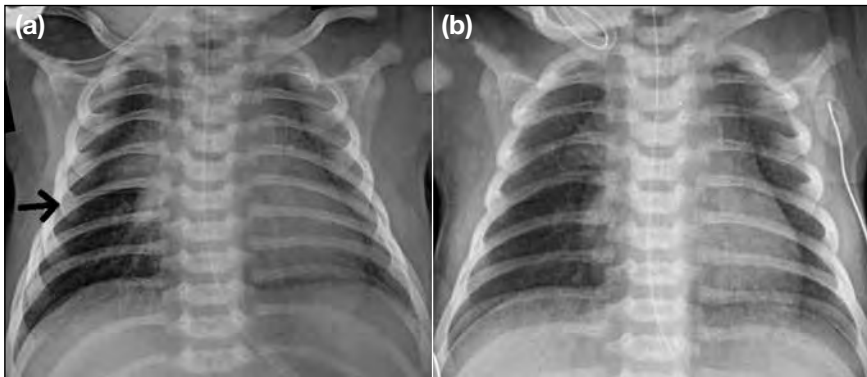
Transient cardiomegaly in transient tachypnoea of the newborn. A 40+4 weeks post-term baby girl delivered by emergent Caesarean section due to failed induction of labour, presented with respiratory distress at birth. (a) Chest X-ray on day 0 showing hyperinflated lungs, increased perihilar streaky opacities and thickened right horizontal fissure (arrow), as well as prominent cardiac shadow. (b) Chest X-ray on day 1 showing interval improvement.
